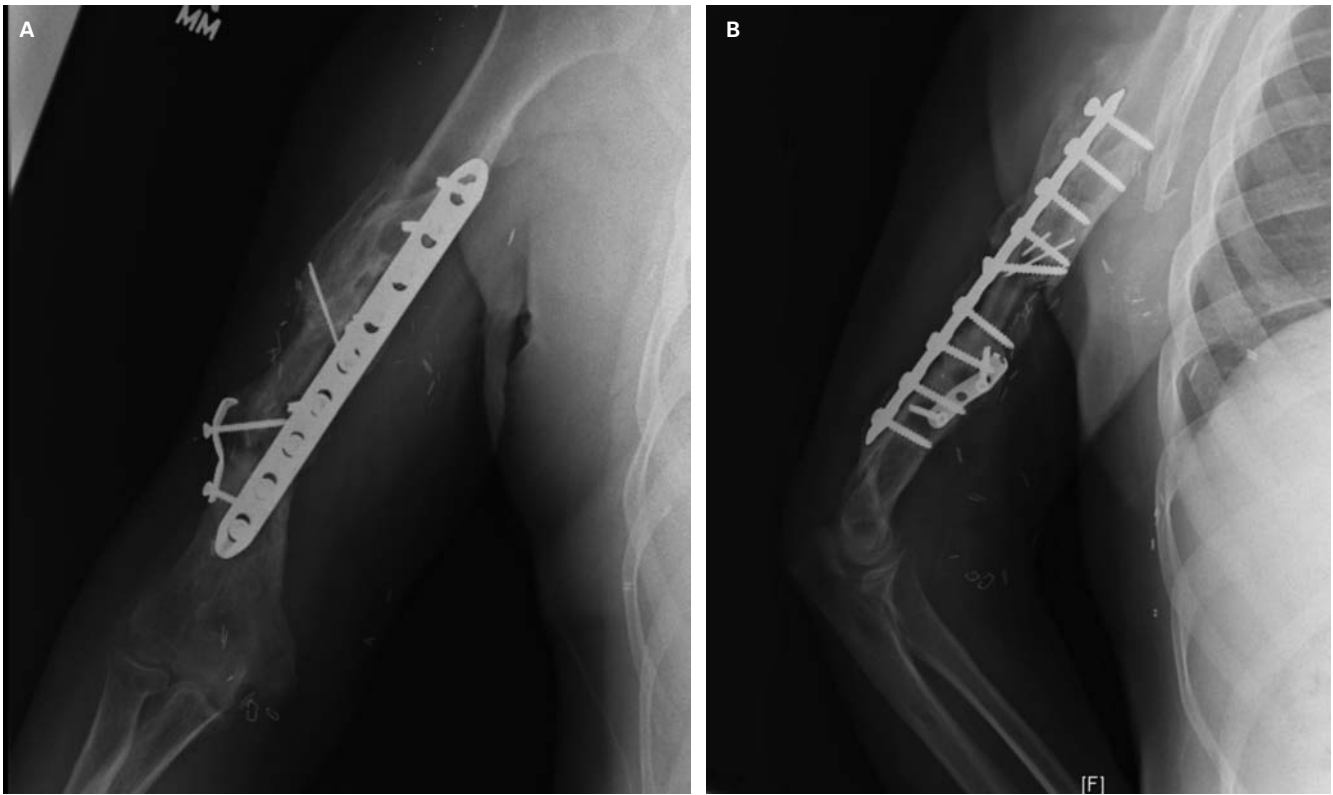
(A & B) AP and lateral radiographs of the distal humerus show healed nonunion. There is no radiographic evidence of an intra-articular elbow pathology.
